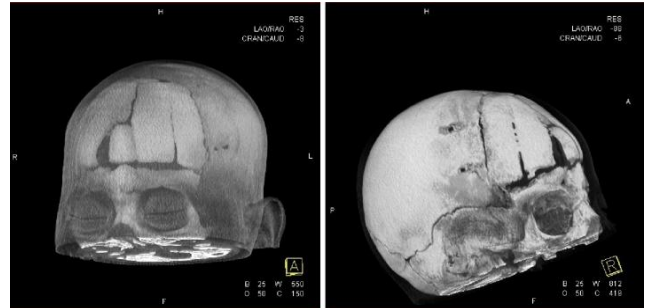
Post-operative 3D reconstructed head CT at 3 months follow up visit
